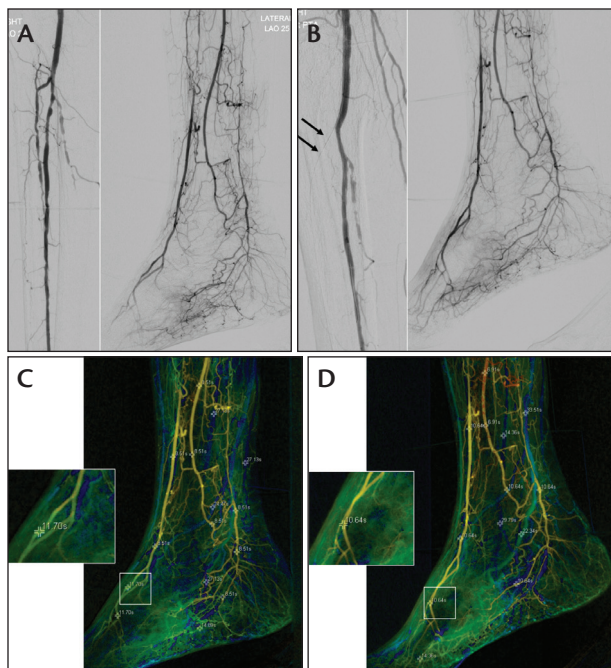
Two-dimensional cone-beam CT perfusion in a 76-year-old woman who presented with a great toe ulcer. Preliminary angiography demonstrated an extensive occlusion of the proximal and mid-anterior tibial artery. There also was high-grade stenosis of the tibioperoneal artery with a good-quality peroneal artery below it, providing collaterals to reconstitute arteries to the foot, including the distal anterior tibial artery (A). The tibioperoneal trunk stenosis was revascularized with a drug-eluting stent, providing indirect revascularization. An attempt to reconstruct the anterior tibial artery (direct revascularization) resulted in occlusion of the proximal segment (arrows), but the distally reconstituted anterior tibial artery was not changed (B). Baseline 2D CT perfusion angiography using i-Flow software (Siemens AG Healthcare). The numbers assigned to each artery represent the time to arrival of contrast after contrast injection via a catheter in the popliteal artery prior to revascularization. Note the time to arrival in the dorsalis pedis artery was measured at 11.7 seconds (C). Two-dimensional CT perfusion angiography after revascularization. The time to arrival of contrast in the dorsalis pedis artery decreased to 10.6 seconds. The great toe ulcer healed within 6 weeks following revascularization (D).
